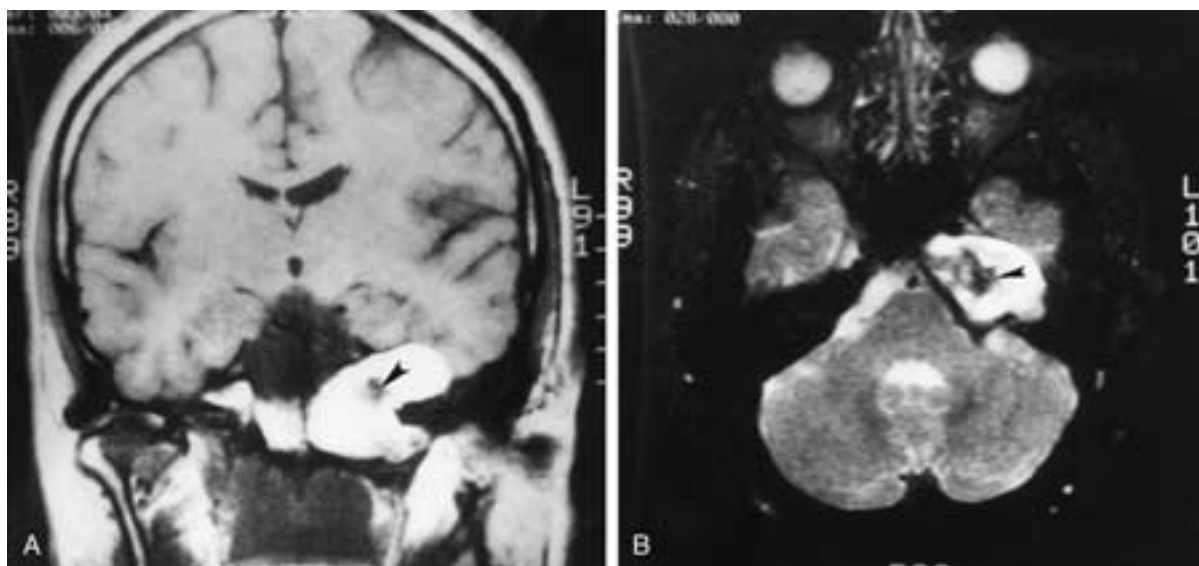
Cholesterol granuloma. A, Coronal T1-weighted image without contrast shows the high signal expansile lesion in the petrous apex. An area of low signal (*arrowhead*) within the abnormality is believed to represent hemosiderin. B, Axial T2-weighted image shows the high signal of the cholesterol cyst. Again, the low signal (*arrowhead*) represented hemosiderin.
